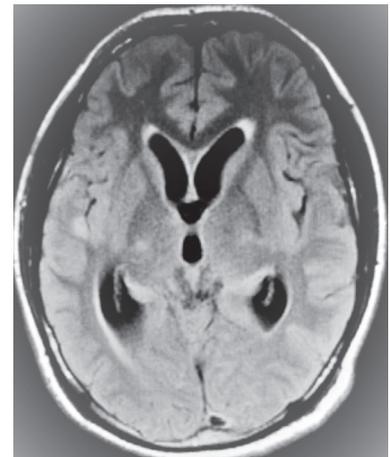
Magnetic Resonance Imaging- in the right temporal lobe and thalamus the strengthened T1+ T2 signals could be noticed, which stipulated that a sizeable part of the brain nodules encounter meningeal enhancement.
